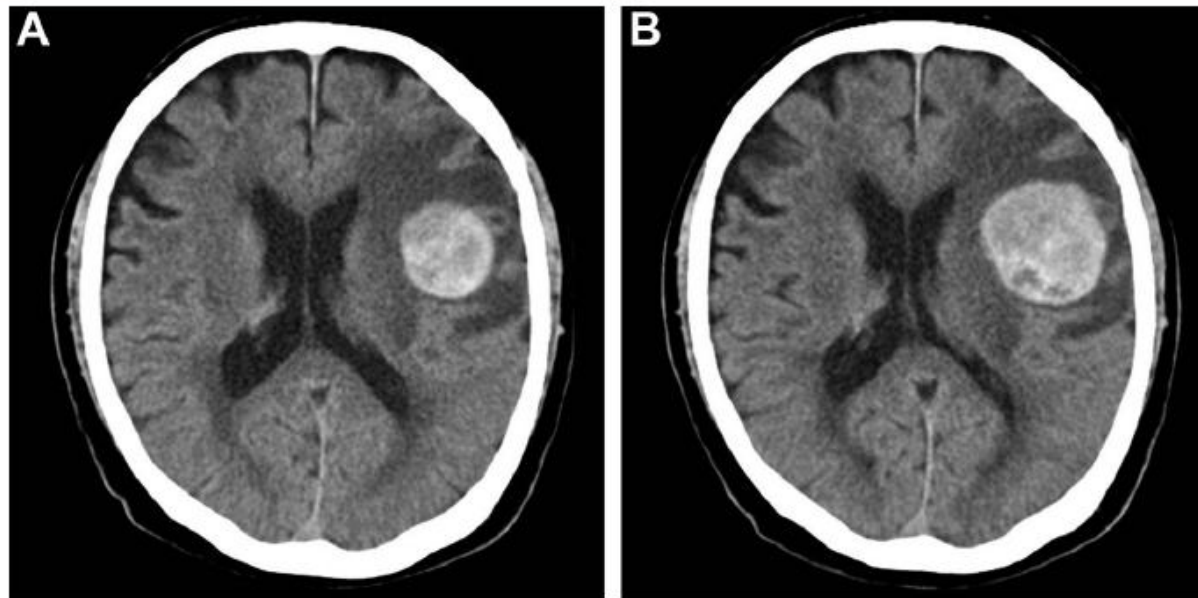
(A) Initial computed tomography (CT) showing a round, high-density mass with surrounded vasogenic edema at the left frontal lobe. (B) Follow-up CT performed 2 weeks after onset shows that the high-density lesion and surrounding edema have increased in size compared with previous images.
